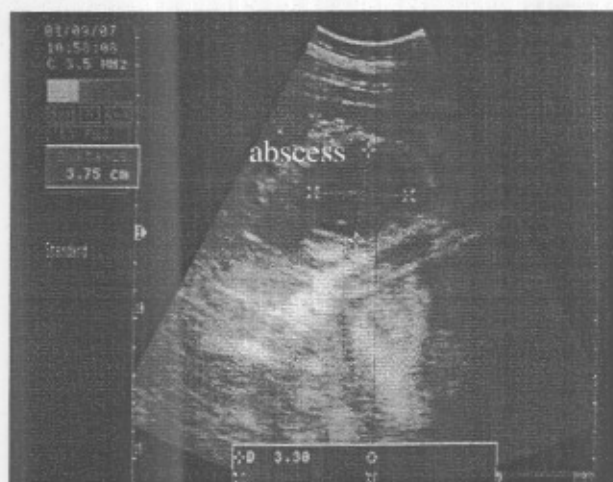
Ultrasonographic image shows small circumscribed mass with echogenic capsule anechoic content with hypoechoic debris (pus cells), located caudoventral in between reticulum and spleen at left side its diameter 3.34 x 3.75 cm. Using 3.5 MHz sector probe.
